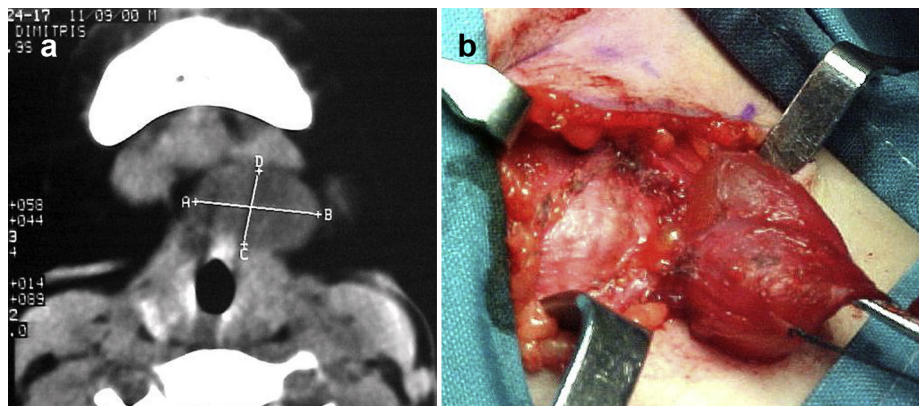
Thyroglossal duct cyst in a 10-year-old female. a: CT imaging presentation – coronal plane. b: Enucleation of thyroglossal duct cyst.
